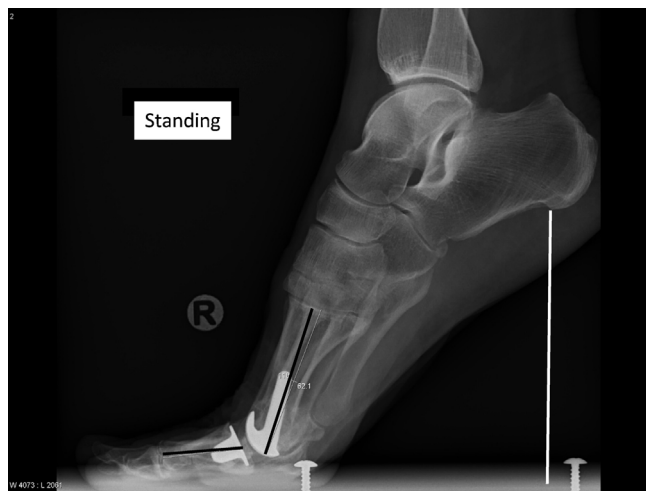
Standing lateral radiograph. Lines for dorsiflexion and heel raise are indicated.
